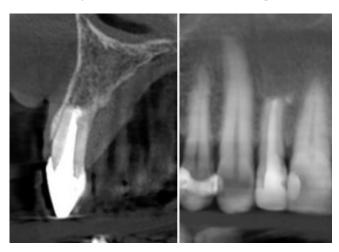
4-year computed tomography follow-up
